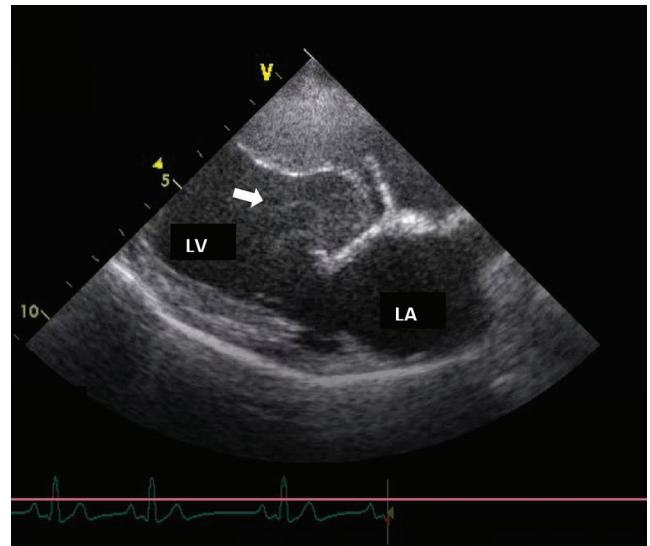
Right parasternal long-axis view of left atrium (LA) and ventricle (LV) showing (arrow) spontaneous echo contrast (SEC)
